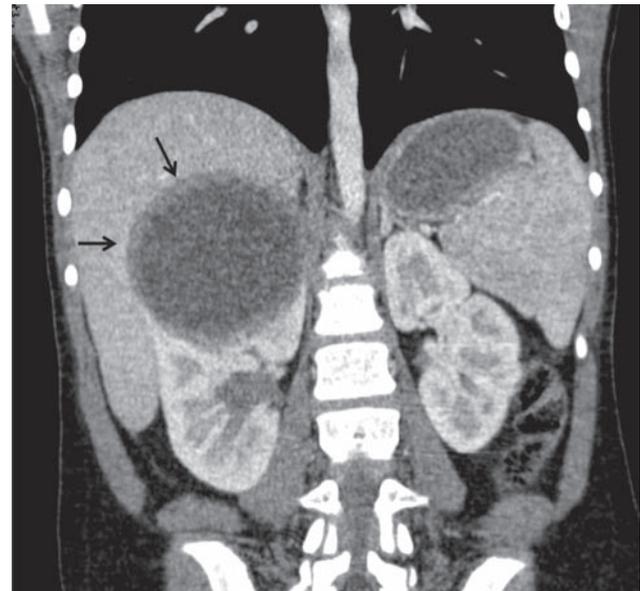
A 9-year-old girl, coronal reformatted contrast-enhanced CT reveals a thick-walled right renal hydatid cyst (arrows).
